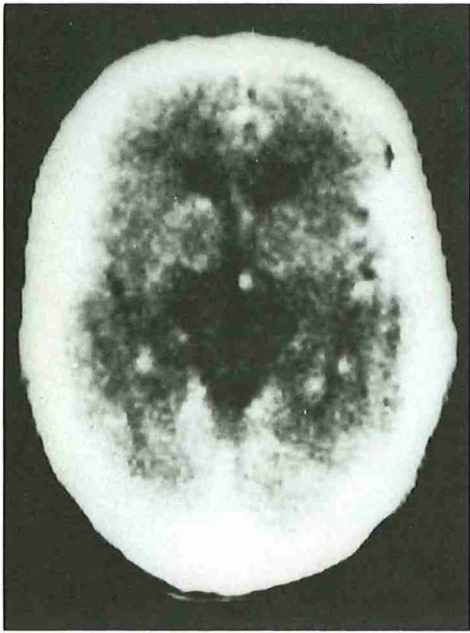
Multiple brain metastases are now visible on CT scan of patient no. 1.
